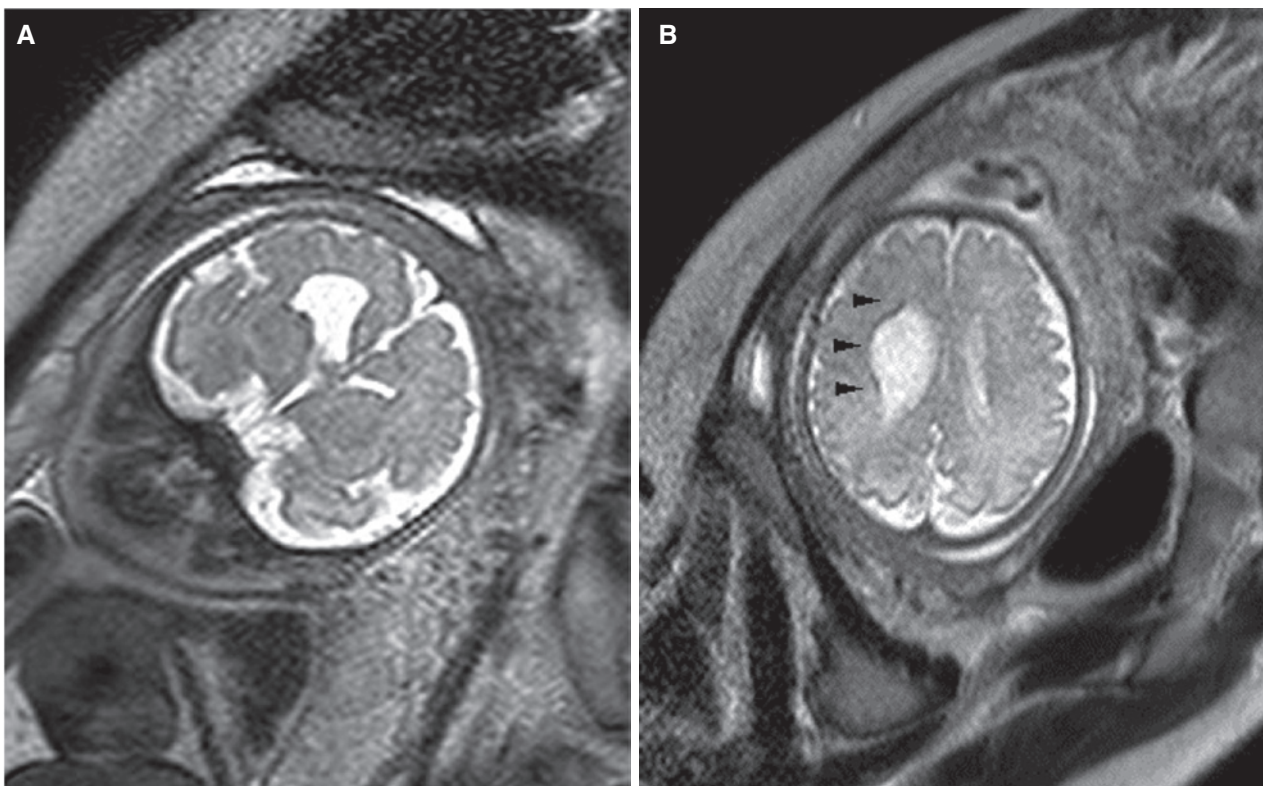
Fetal magnetic resonance imaging at 34 weeks of gestation. (A) Enlarged right lateral ventricle and spared cerebral cortex on coronal T2-WI. (B) Liner low signal intensity along the focally enlarged right lateral ventricle on axial T2-WI (black arrowheads).
